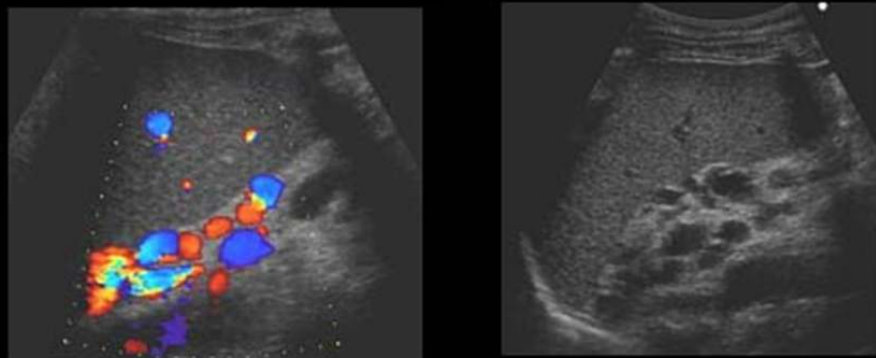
Color Doppler image of splenorenal collaterals.
